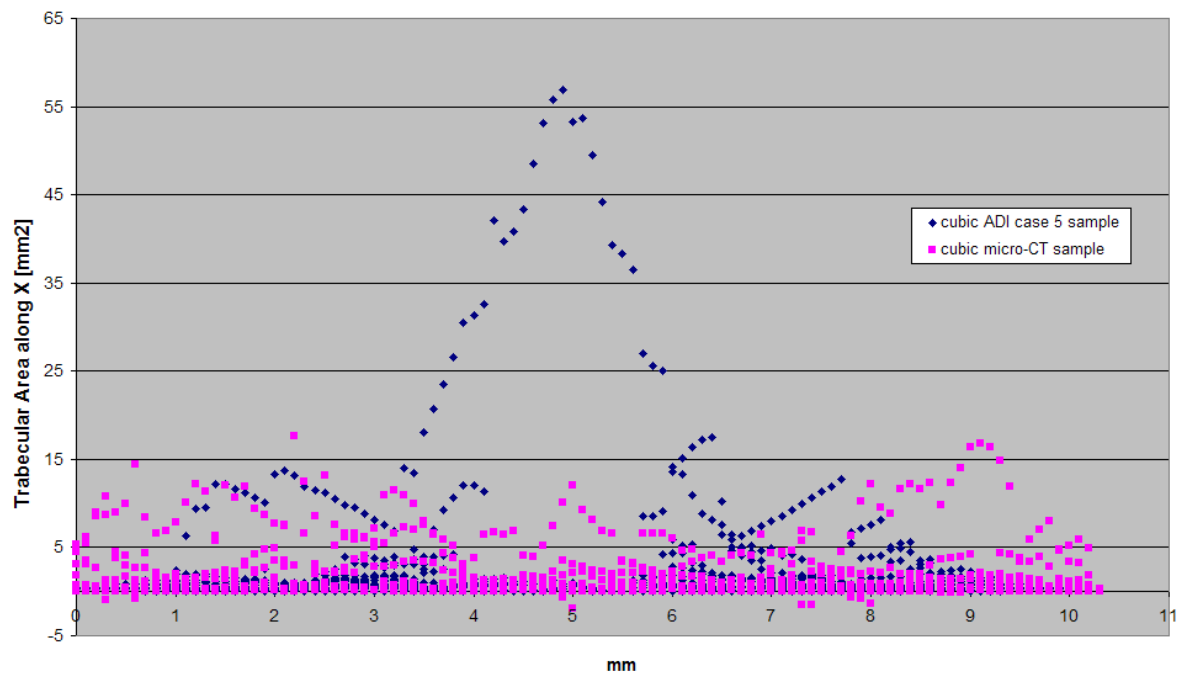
Comparison of sliced area along *X* between the cubic ADI case 5 sample and cubic  $\mu$ CT sample
